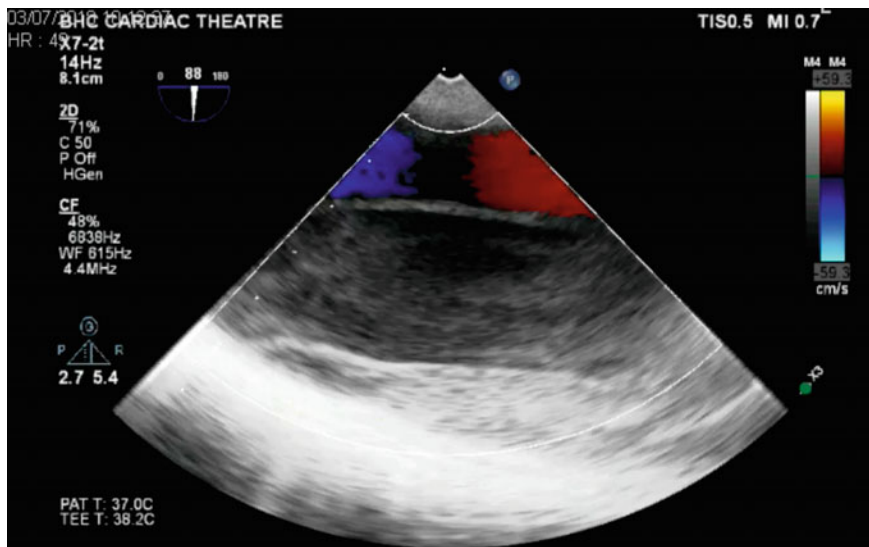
Descending Thoracic Aorta TOE long axis view demonstrating an aortic aneurysm with chronic type B dissection. Colour doppler examination reveals flow in the smaller true lumen with a larger false lumen with ‘smoke’ due to stagnant flow
